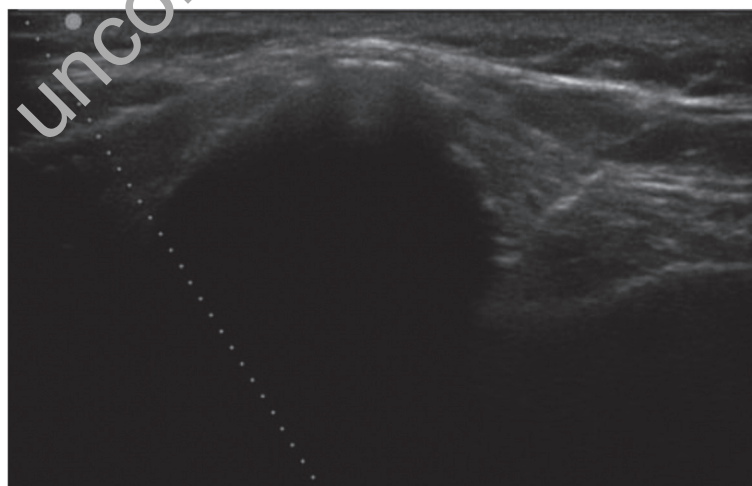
PRP-injections performed under ultrasound guidance.
